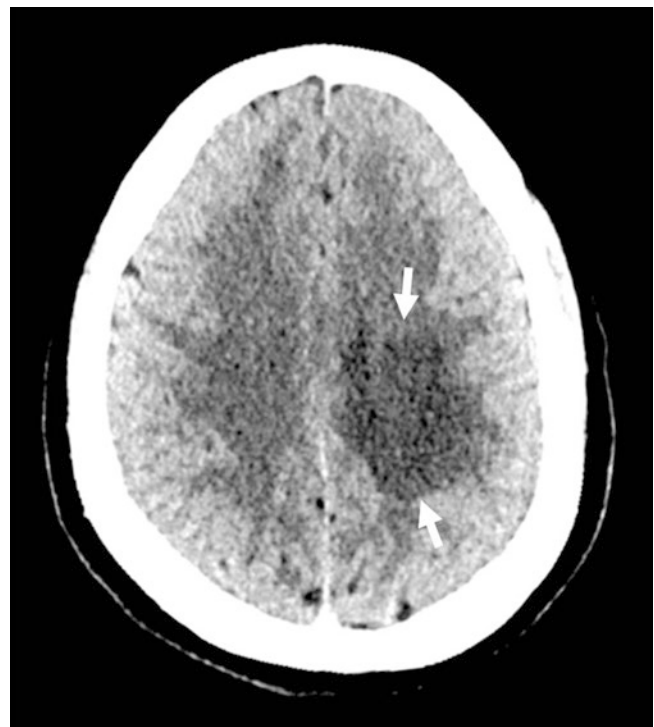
Axial CT of the head showing a large hypoattenuating (hypodense) lesion in the left frontoparietal subcortical white matter (arrows). The lesion produces mild mass effect on adjacent structures
